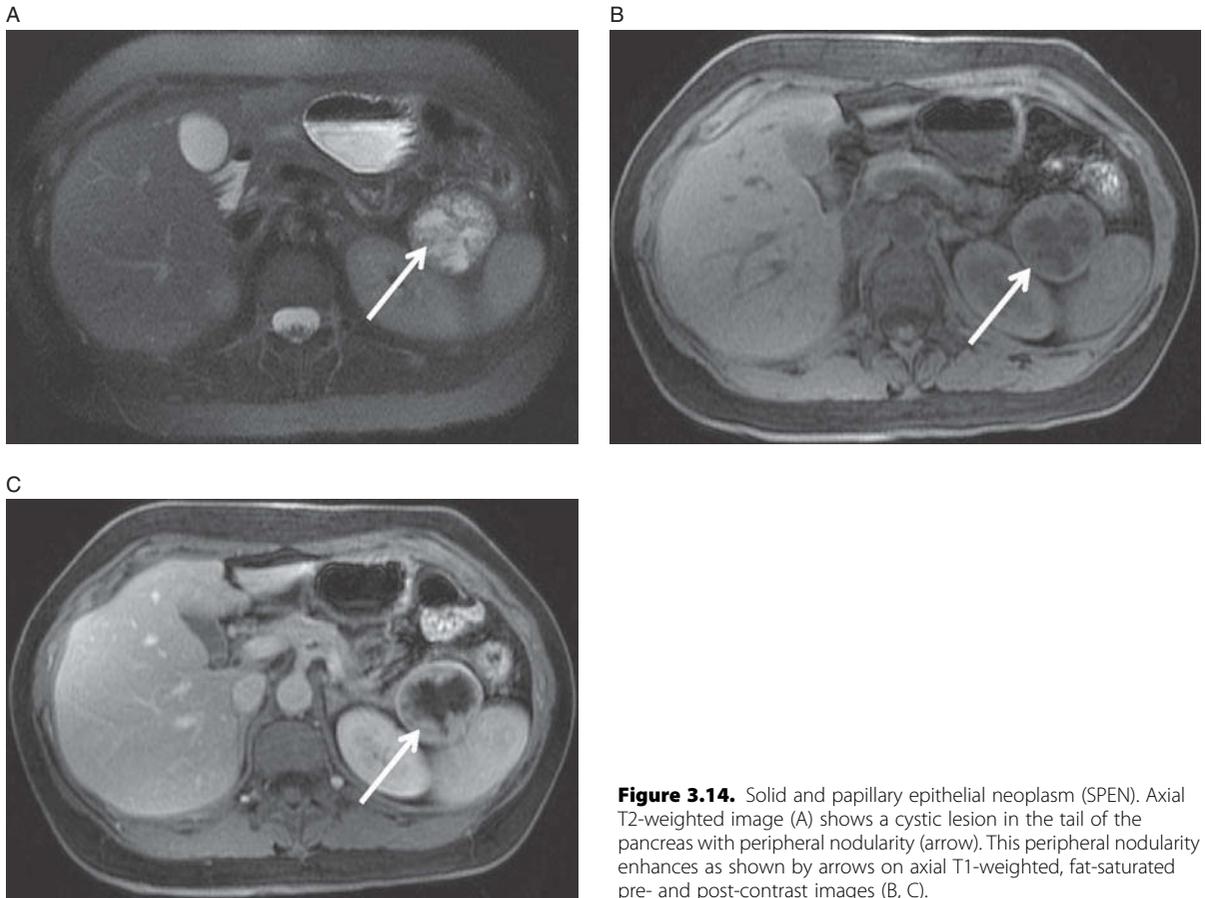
Solid and papillary epithelial neoplasm (SPEN). Axial T2-weighted image (A) shows a cystic lesion in the tail of the pancreas with peripheral nodularity (arrow). This peripheral nodularity enhances as shown by arrows on axial T1-weighted, fat-saturated pre- and post-contrast images (B, C).
